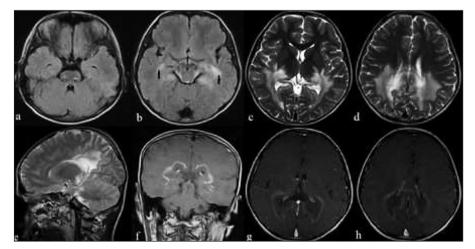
The patient's cranial MRI findings. Axial T2-weighted images reveal abnormal hyperintense lesions including bilateral central pons, anterior bulbus, anterior cerebral peduncles, and corticospinal tracts (a, b), Auditory tract and visual tract demyelination involving the region of parietooccipital and posterior temporal white matter (b-d), Sagittal T2W image shows abnormal hyperintense lesion in splenium of the corpus callosum (e), Post contrast T1W images show contrast enhancement of the parietooccipital region (f-h).
